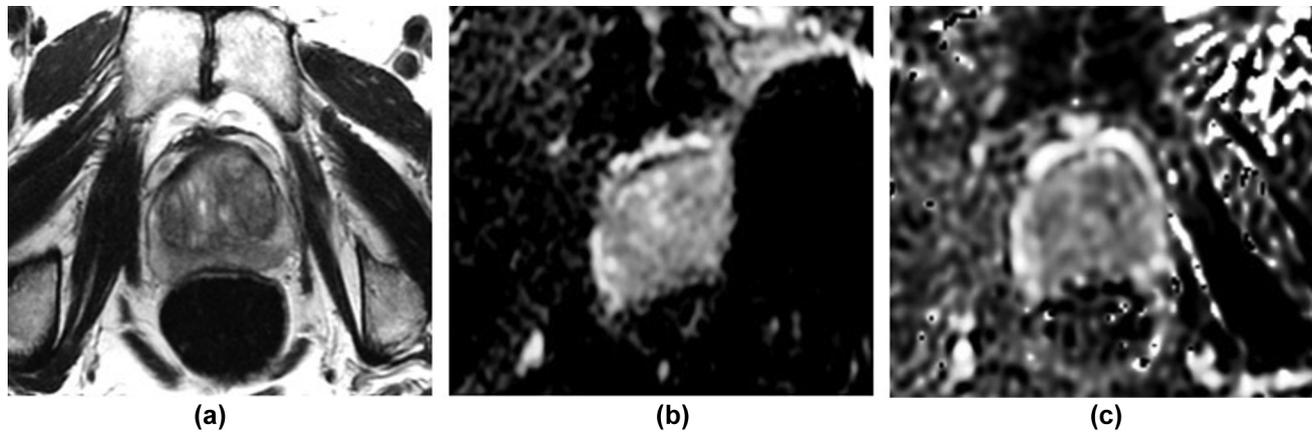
THR artefact on DWI improved with PROPELLER 71-year-old patient with left THR imaged at 1.5 T. (a) T2 WI. (b) ADC map from EPI-DWI shows warping and distortion. (c) ADC map from PROPELLER-DWI has little artefact or distortion (note streak artefact from THR in the top right-hand side of the image).
